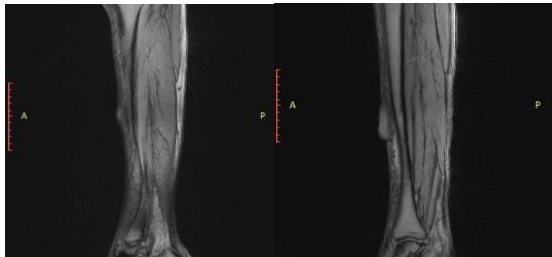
MRI of both lower limb showing depth.
